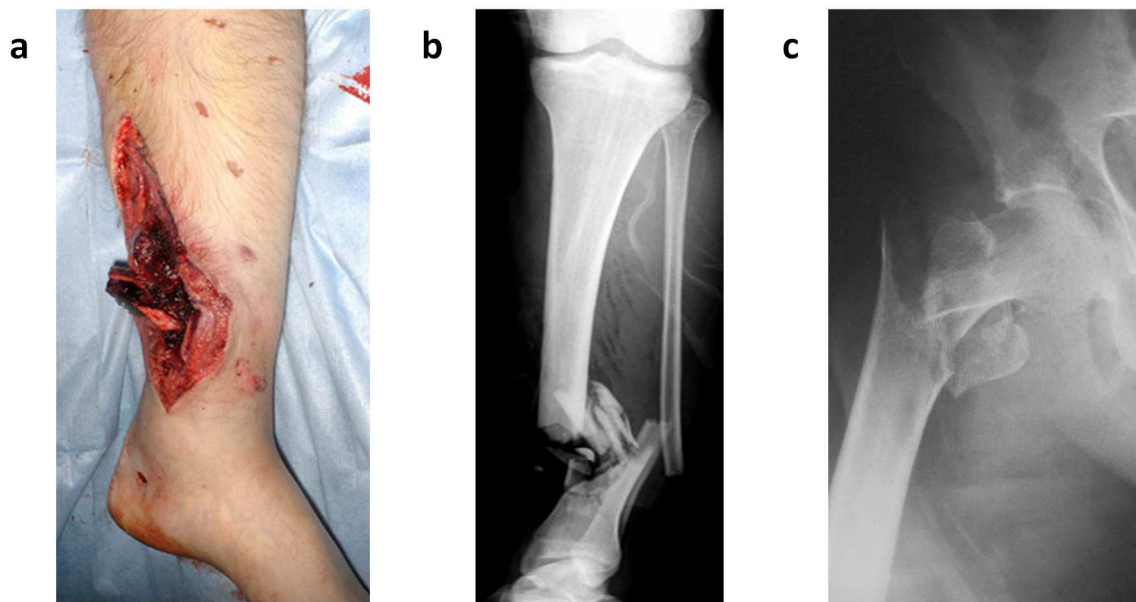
(a) Clinical photograph of high energy open tibia-fibula fracture with (b) corresponding anterior-posterior (AP) radiograph. (c) AP radiograph of an intertrochanteric hip fragility fracture.
